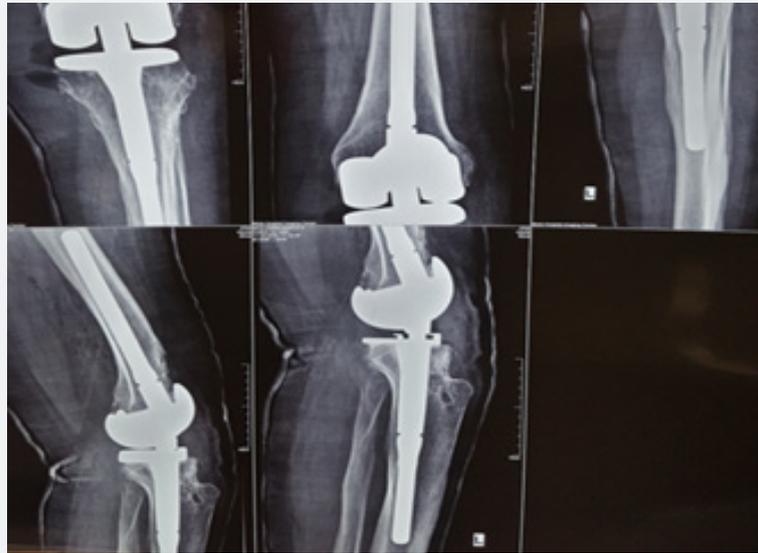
Left knee post-operative X-ray.
